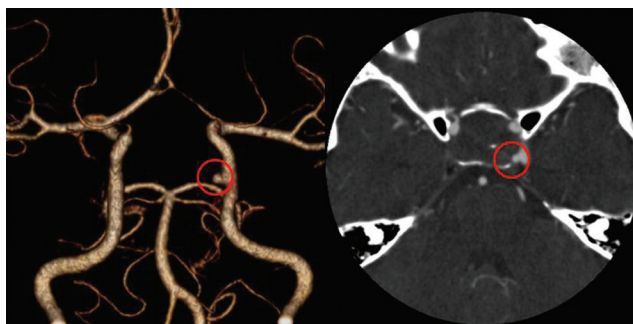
Three-dimensional computed tomography angiography. Images show a small aneurysm (circle) of the patient’s left internal carotid artery.
